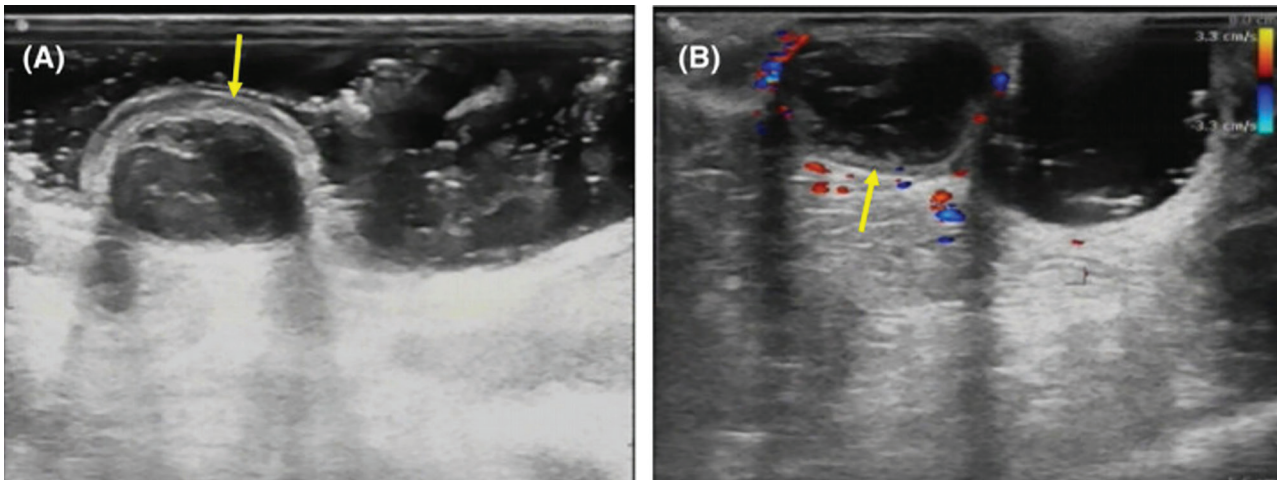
Endoscopic ultrasound. (A) Grayscale ultrasound shows a cystic mass in the submucosa with a clear boundary, poor internal transmission, and continuous echogenicity in the mucosal layer (yellow arrow). (B) Color Doppler ultrasound shows a small amount of blood flow signal around the cystic mass, no obvious blood flow signal inside, and continuous echogenicity in the serous layer of the intestinal wall (yellow arrow). Image source: Jiang et al. (Reference 5)); reused under the terms of the Creative Commons Attribution License <http://creativecommons.org/licenses/by-nc-nd/4.0/>
